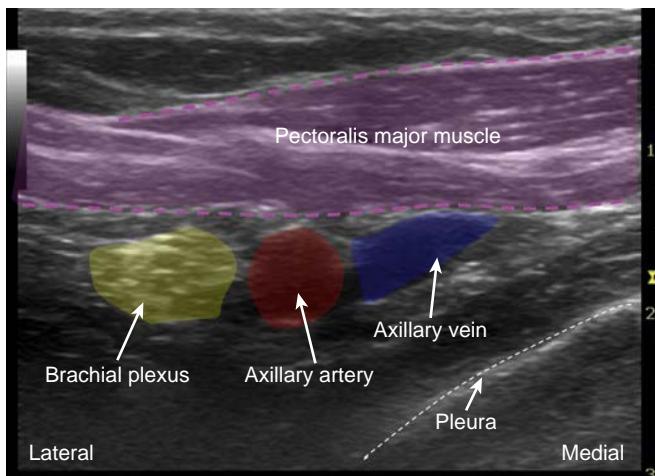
Ultrasound infraclavicular block, infraproximal approach. At this proximal level, the pectoralis major is the main muscle seen superficial to the neurovascular bundle. The pectoralis minor is located distally to this ultrasound section. Among the neurovascular bundle structures the axillary vein is the most medial, followed by the axillary artery and then the divisions of the plexus most laterally.
